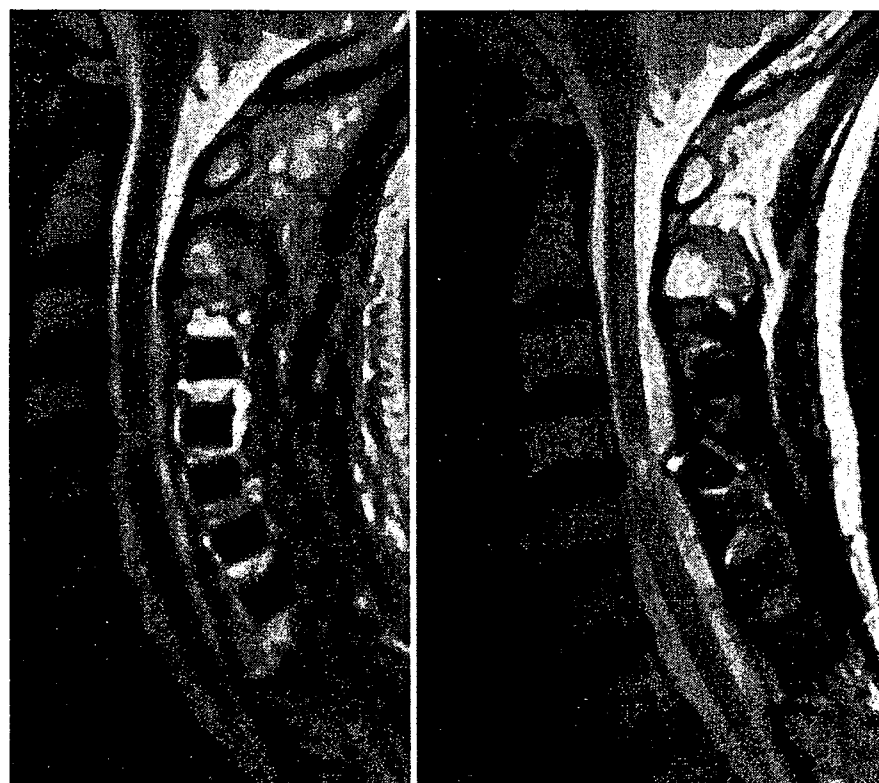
Case 1. Sagittal MR imaging studies. An image obtained 6 months postoperatively (*left*) demonstrates no compression of the spinal cord. The 5-year postoperative image (*right*), however, demonstrates dural sac compression caused by the hydroxyapatite intraspinal spacer at C-4.
